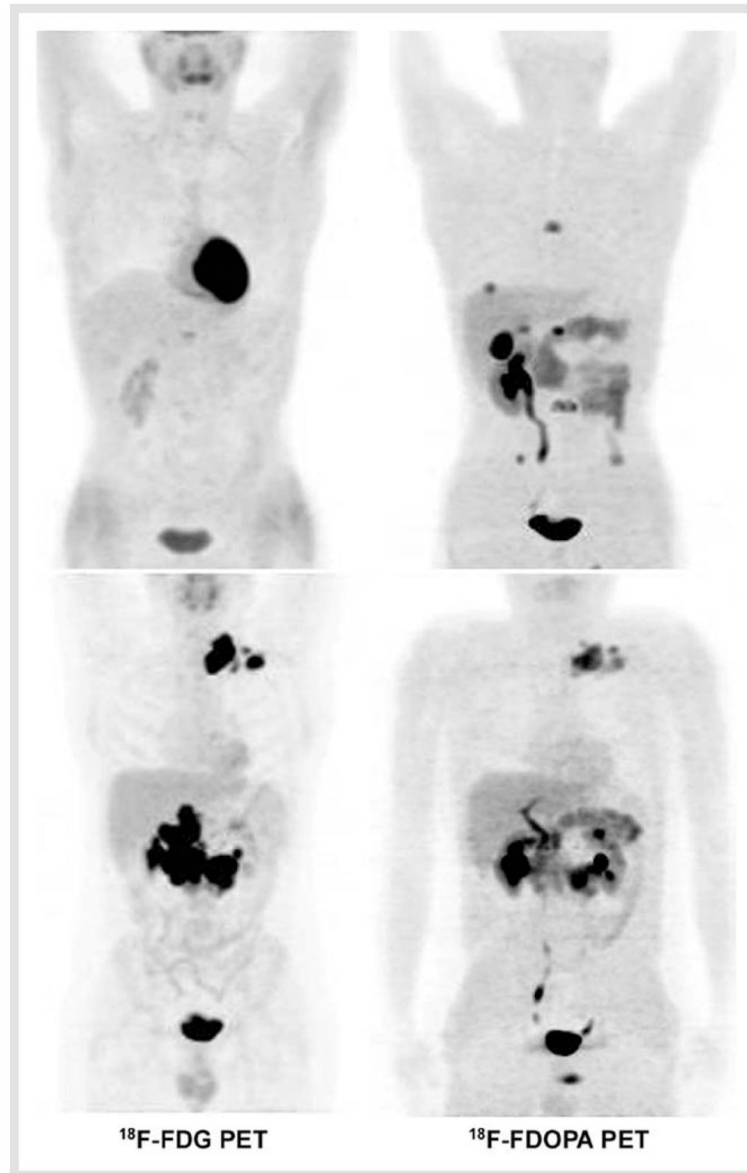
Comparison between ^{18}F -FDOPA and ^{18}F -FDG PET in 2 patients with metastatic PPGL (maximal intensity projection images). SDHB-negative patient (upper images). SDHB-positive patient (lower images). ^{18}F -FDOPA was clearly superior to ^{18}F -FDG PET in SDHB-negative PPGL and vice versa in the SDHB-related case.
